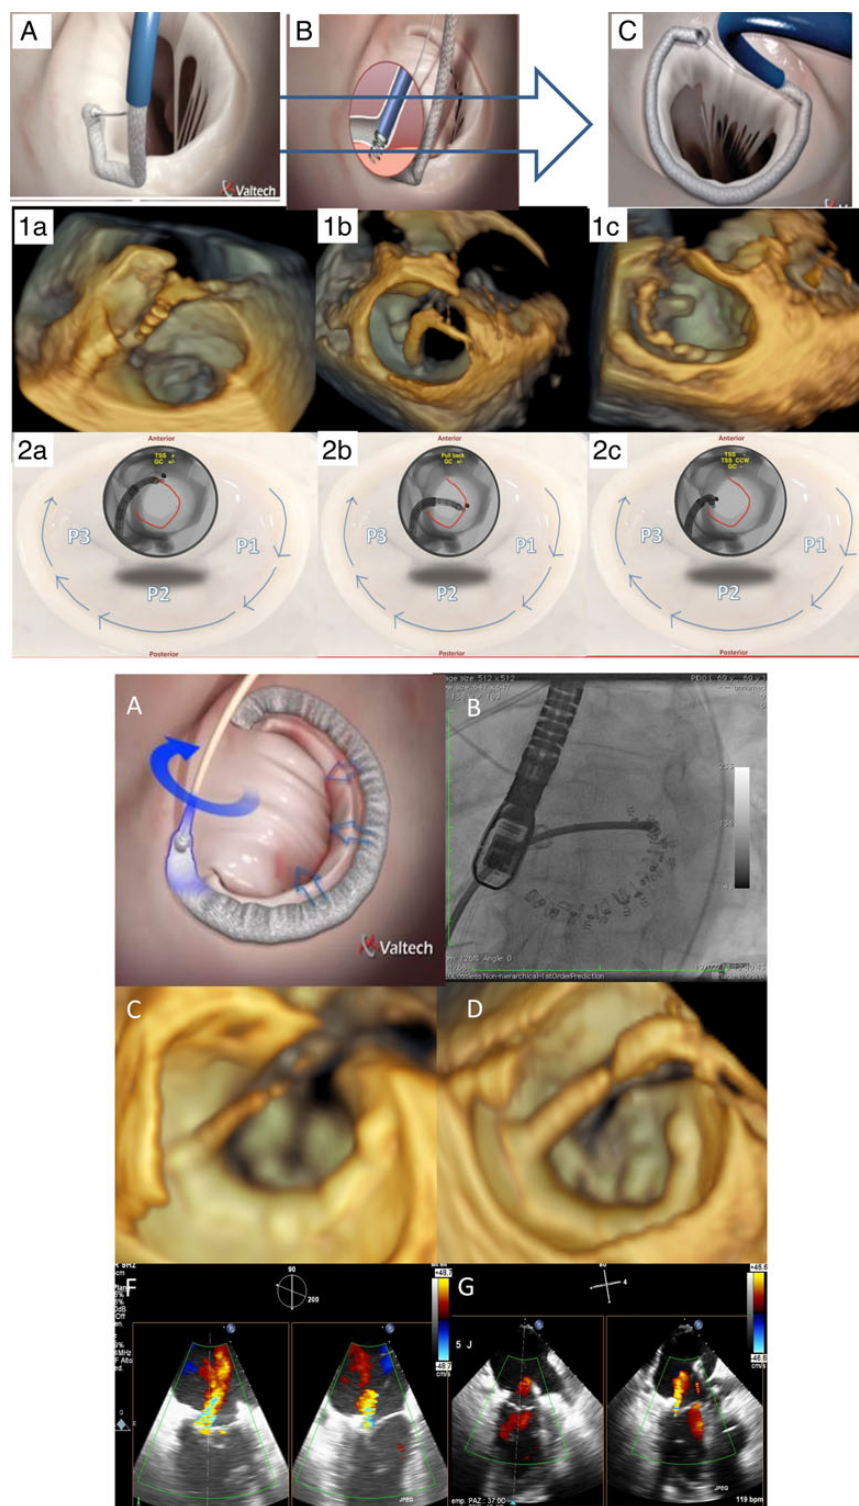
(A) The Valtech Cardioband. The system consists of an adjustable annuloplasty band, which is delivered via the transseptal approach into the atrial site of the posterior mitral annulus between the antero-lateral (A) and postero-medial commissures (C) with helical fixation anchors (B). The delivering phase requires step-by-step monitoring using 3-D echocardiography (Figure 1A–C) and fluoroscopy (Figure 2A–C). Starting from the antero-lateral commissure (Figures 1A and 2A), the Cardioband is progressively delivered and completed at the postero-medial commissure (Figures 1C and 2C). Fluoroscopy imaging (ventricular view) mirrors 3D echocardiography (atrial view). P1, P2, and P3 are the referral landing zones corresponding to the lateral scallop, middle scallop, and the medial scallop of the posterior mitral leaflet respectively. (B). (A) Following complete delivery, the Valtech Cardioband system ((B) fluoroscopy imaging) is adjusted under 3D echocardiography to reshape the annulus (C and D) to achieve reduction of mitral regurgitation ((F, G): colour-flow mapping at baseline and after the final adjustment, respectively).
